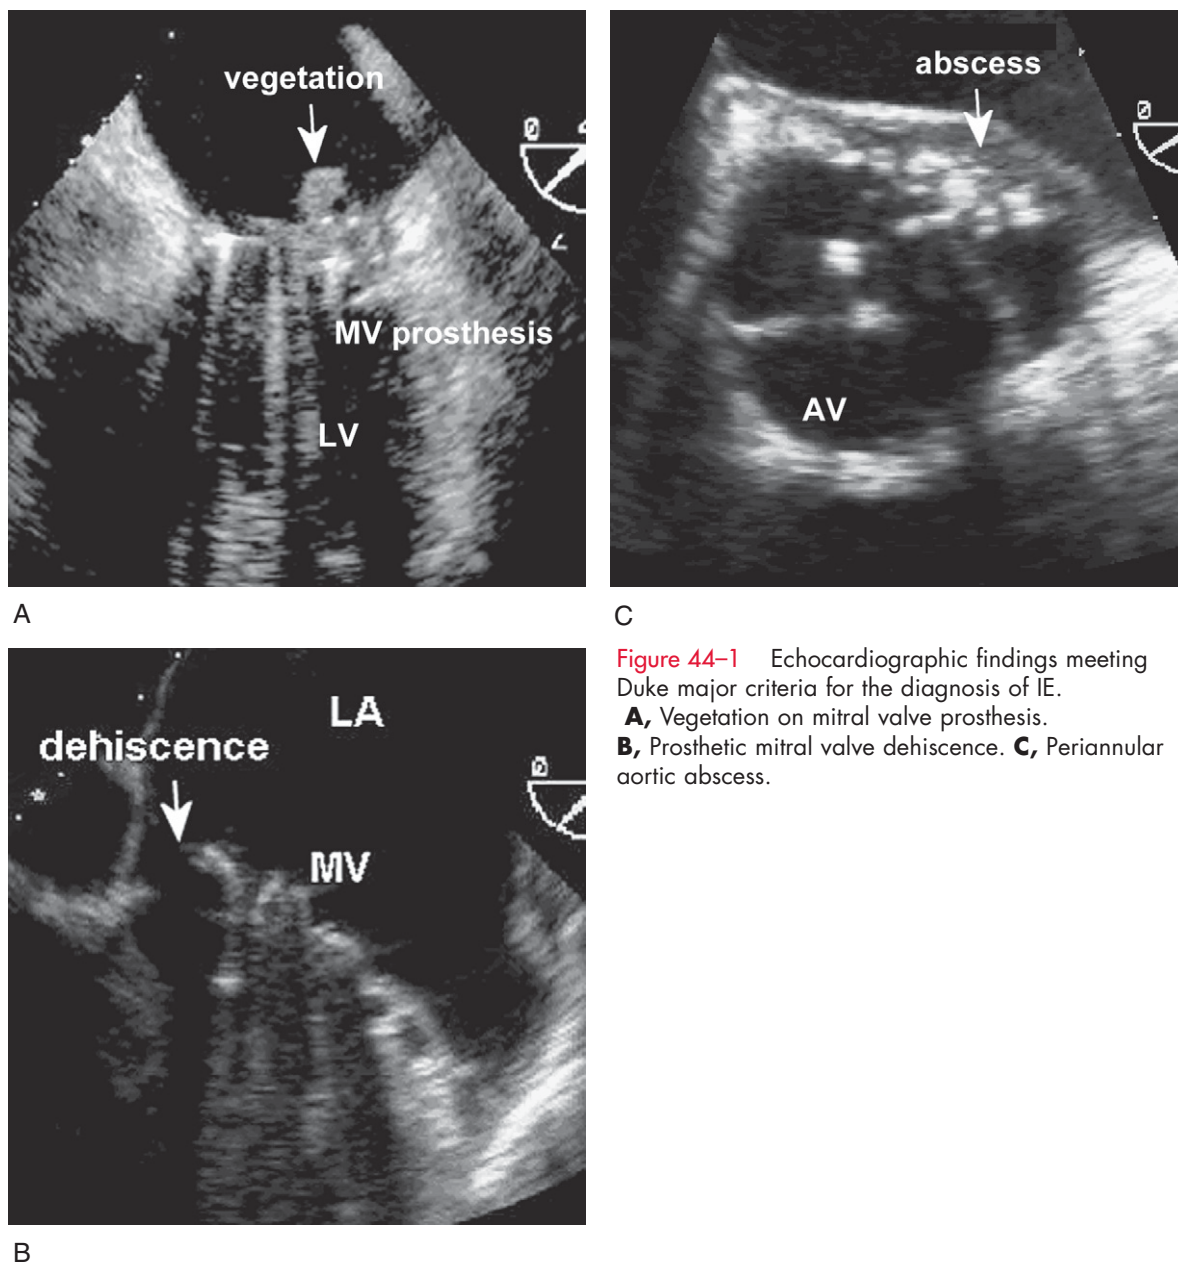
Echocardiographic findings meeting Duke major criteria for the diagnosis of IE. A, Vegetation on mitral valve prosthesis. B, Prosthetic mitral valve dehiscence. C, Periannular aortic abscess.
